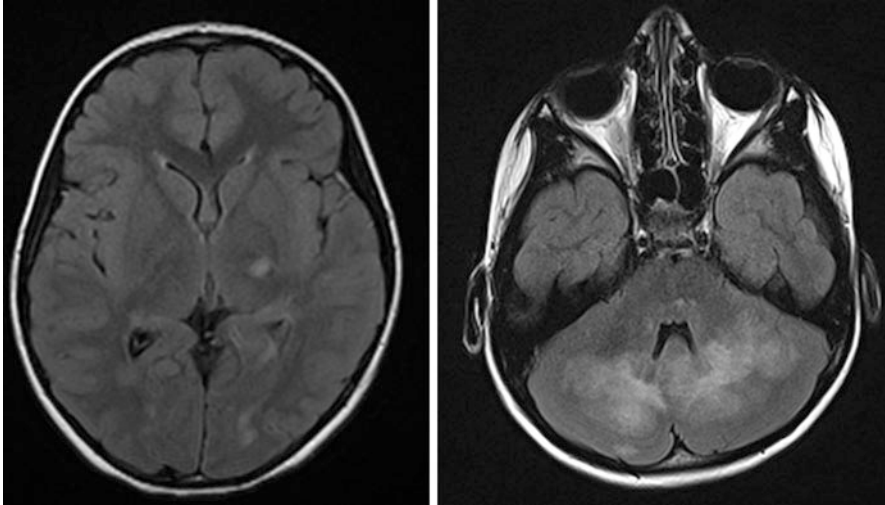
ADEM Mimics. Axial FLAIR showing white matter involvement in the deep white matter and cerebellum in a 5-year-old female with CNS-isolated HLH due to perforin 1 gene mutation, who was initially diagnosed as relapsing ADEM triggered by Varicella immunization
